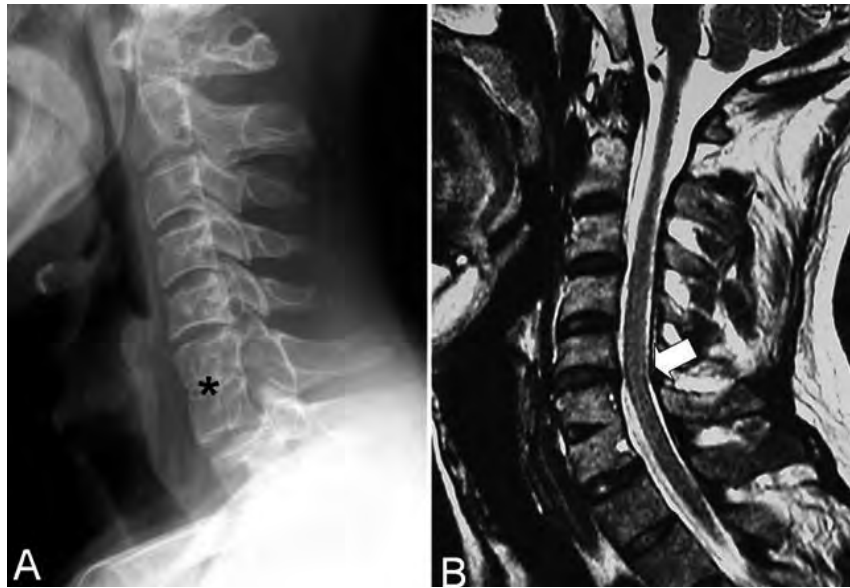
A) lateral cervical spine radiograph showing a correction of physiological cervical lordosis and congenital C6-C7 vertebral fusion (asterisk). The fusion is observed in both the cell bodies and the posterior elements, and the narrowing of the central somatic block at the level of theoretical disc space, as often happens in congenital fusion. B) MRI, fast spin-echo (FSE) T2 sagittal sequence. Spinal signal is virtually normal, with slight ill-defined enhancement of the spinal cord signal, but without contusive points. Degenerative disc phenomena immediately above the cervical block slightly constrict the central canal and obliterate the subarachnoid space (arrow).
